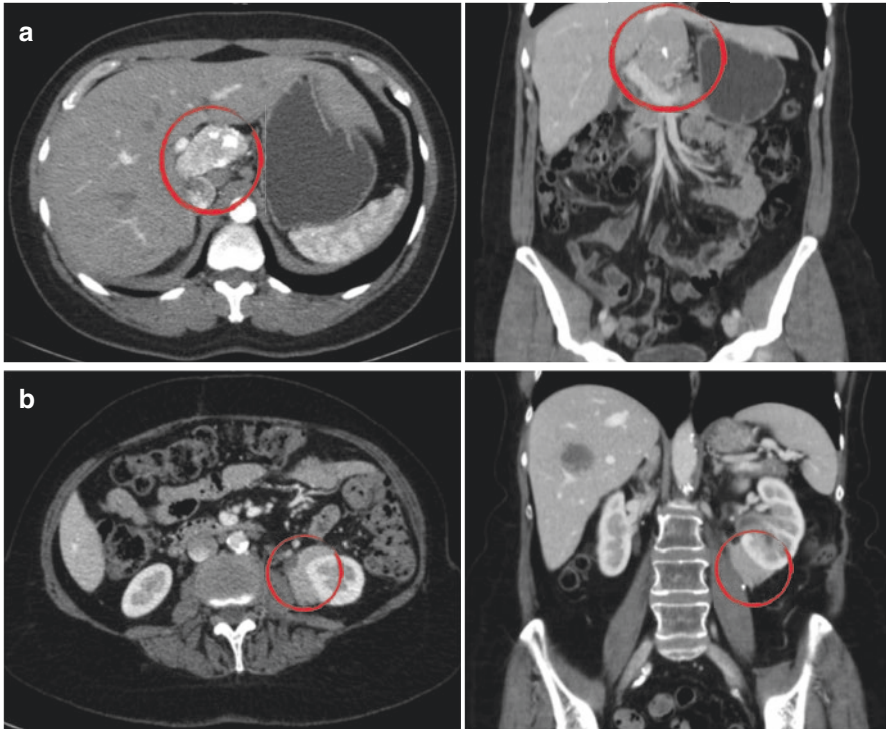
(a) Example of the hyaline-vascular type: vascularized nodular lesion superior to the head of the pancreas and close to the hepatic hilum, with enhancement in the arterial phase, with calcifications inside. In the present case, the lesion has contact with the portal vein and is associated with some adjacent arterial collaterals, probably related to its irrigation. (b) Example of the plasmocytic type: An infiltrative and vascularized lesion next to the medial aspect of the left kidney, involving the collecting structures, with homogeneous contrast enhancement observed on CT. The liver lesion is a hemangioma. (Courtesy of Hilton Leão Filho, radiologist)
